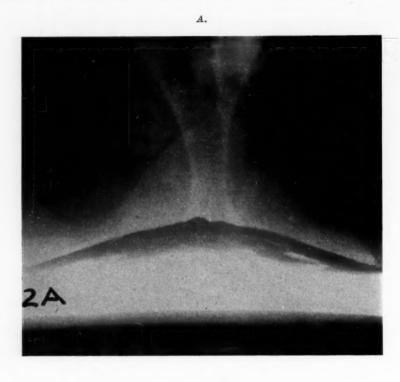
A, Shows x-ray of patient with wire in place, sitting on hard chair. The wire is above the surface of the chair.
